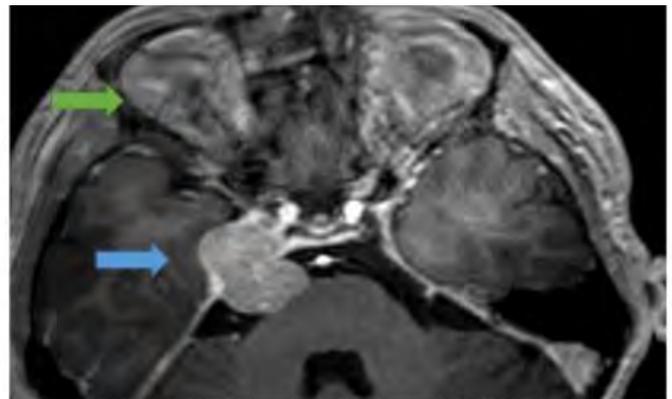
MRI brain with IV contrast
